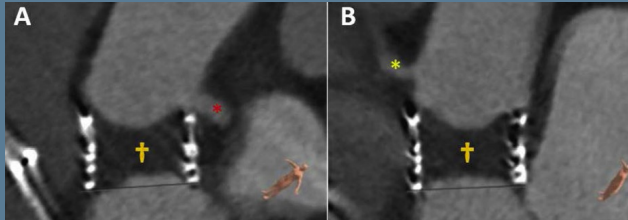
(A) Postprocedural computed tomography (CT) shows the ostium and proximal portion of the left main coronary artery (red asterisk) and significant thrombus within the implanted transcatheter aortic valve (orange dagger). (B) Postprocedural CT shows the ostium and proximal portion of the right coronary artery (yellow asterisk).
